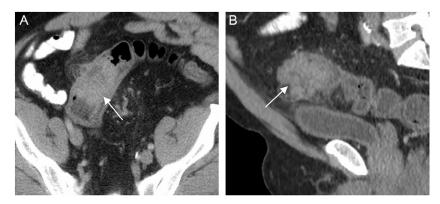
Coronal (A) and sagittal (B) computed tomographies demonstrating an eccentric mass-like focal thickening (arrows) of the sigmoid colon measuring  $3.9 \times 3.2$  cm, which proved to be colon adenocarcinoma.
